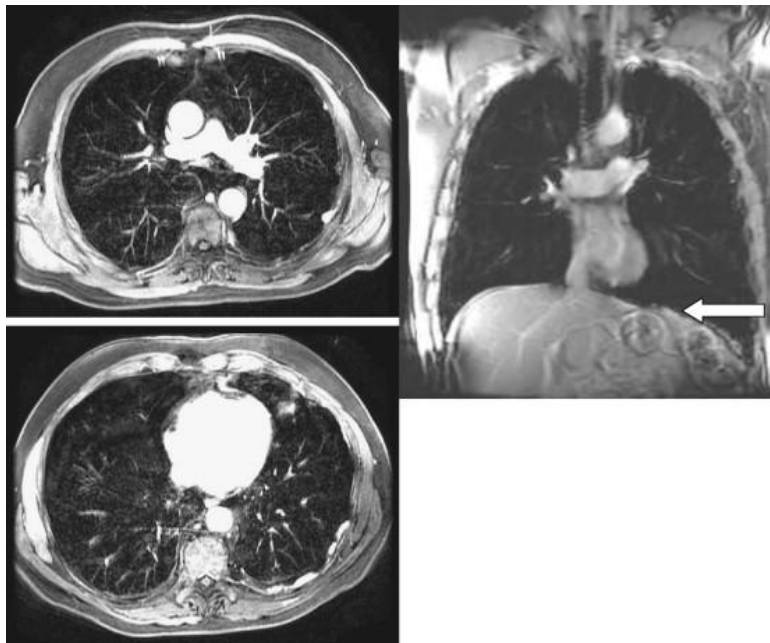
Contrast enhanced coronal T1-weighted image and axial LAVA images of a patient diagnosed with pleural mesothelioma, revealing circumferential pleural nodules, without diaphragmatic (white arrow) or chest wall invasion [9].
